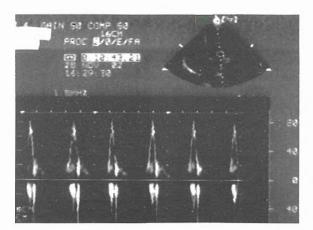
The mitral inflow pulse-wave Doppler examination after 5-FU treatment showing restrictive pattern of diastolic dysfunction
